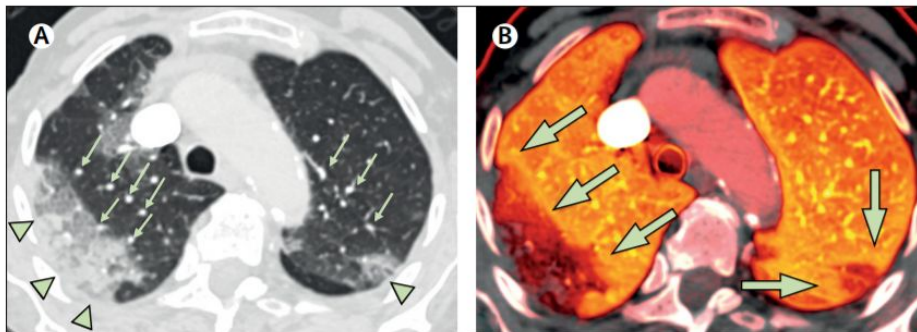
Dual-energy CT in a patient with COVID-19 pneumonia without evidence of pulmonary emboli
